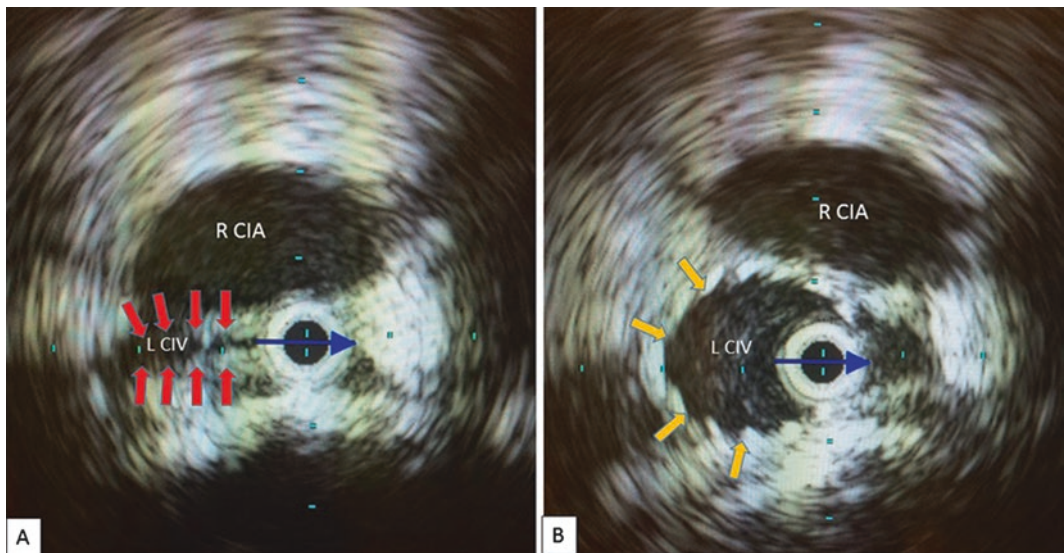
Intravascular ultrasound (blue arrow) demonstrating left CIV compression (A—red arrows) by the overlying R CIA. The lesion is expanded after stenting
